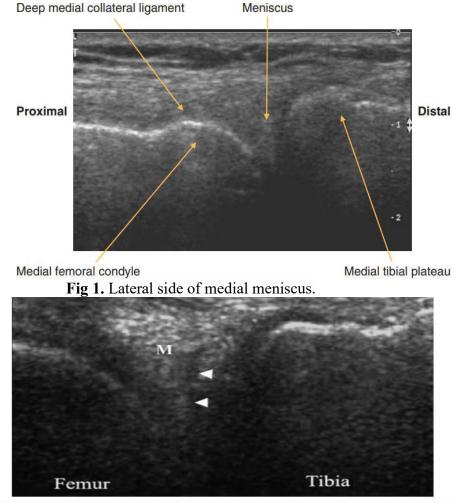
Longitudinal ultrasonography obtained through the posterior horn of the medial meniscus showing a discrete hypoechoic cleft extending to the tibial articular surface of the hyperechoic meniscus.
